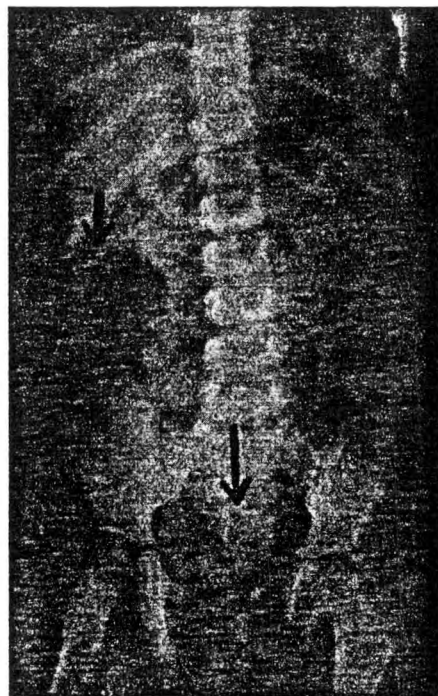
X-ray of the abdomen of a patient with chronic lead poisoning showing flecks of lead-containing material (paint) along the course of the intestines (arrows).
